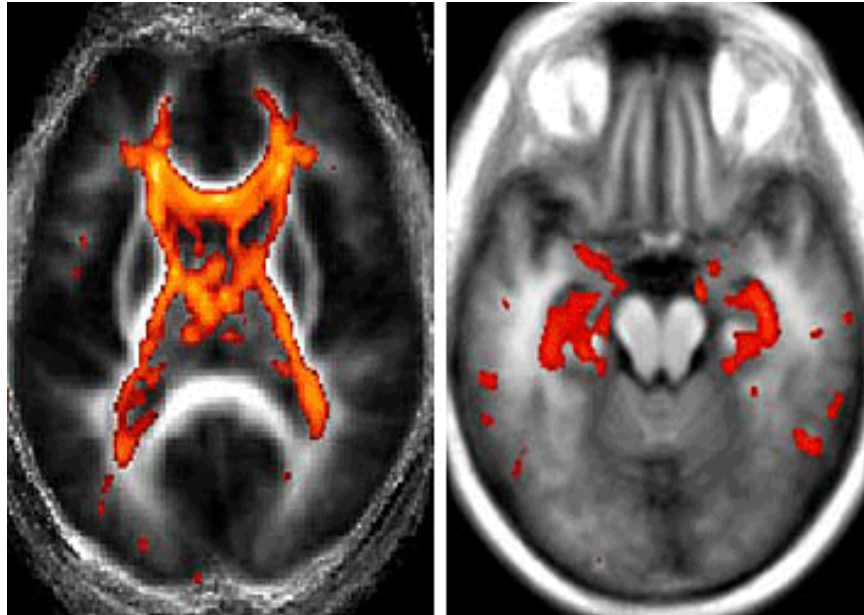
Image Title: Distinct MRI methods reveal changes associated with normal aging, which occur in frontal regions, and those prominent in Alzheimer's disease, which affect the hippocampus. Areas of color show regions of change for aging (left image) and Alzheimer's disease (right image). - Courtesy of Randy L. Buckner and Denise Head, HHMI at Washington
